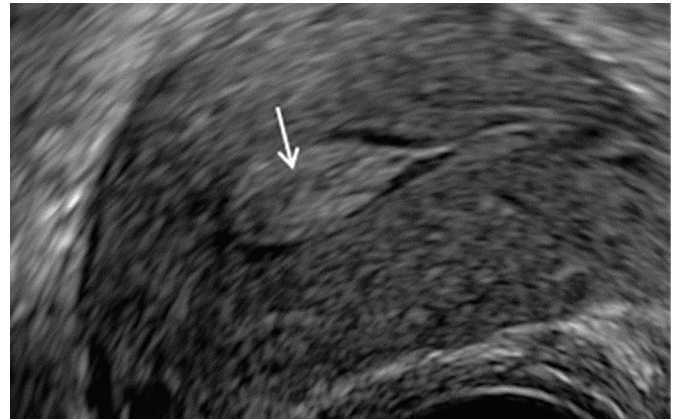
Transvaginal ultrasound: isoechogenic polyp filling the uterine cavity.<sup>4</sup>
